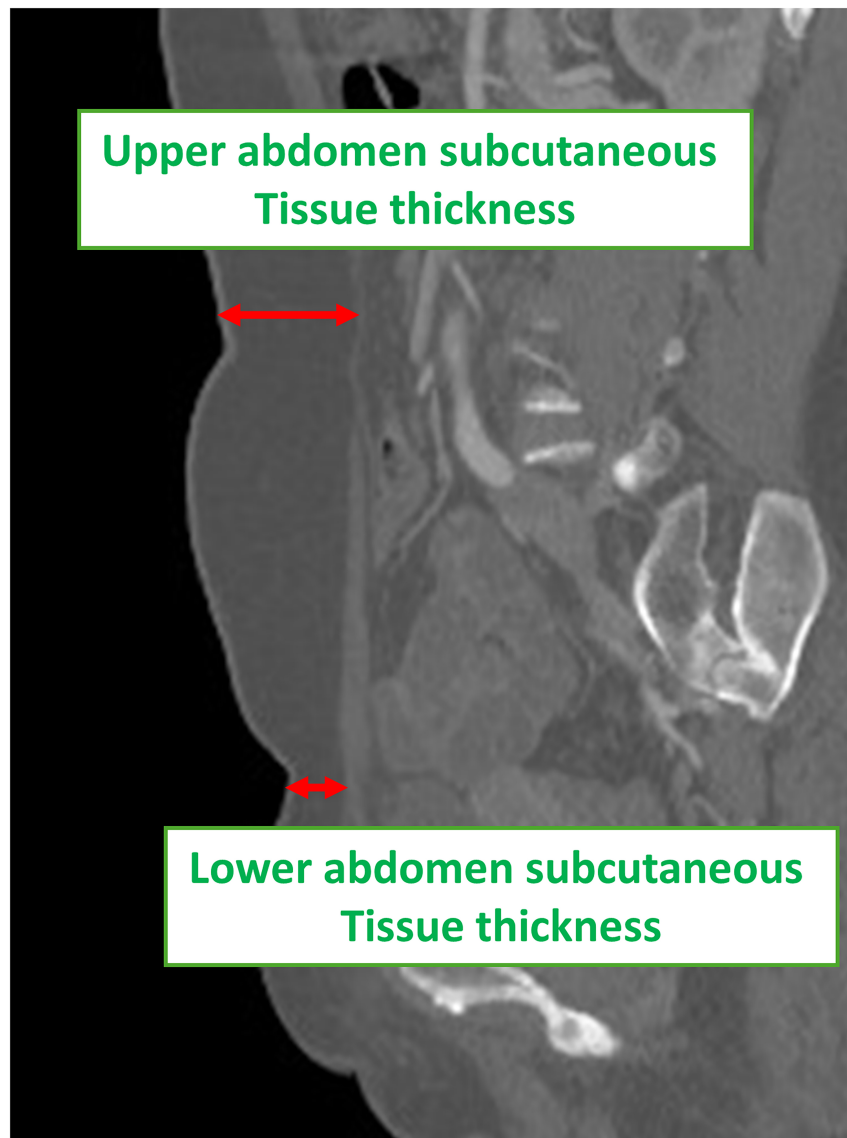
Preoperative CTA measured the maximum subcutaneous tissue thickness in the upper and lower abdominal regions, focusing on the umbilicus level and midway between the anterior superior iliac spine and pubic symphysis. Differences in thickness exceeding 9.5 mm were considered indicative of risk factors for developing a step-off deformity. CTA: Computed tomography angiography.
